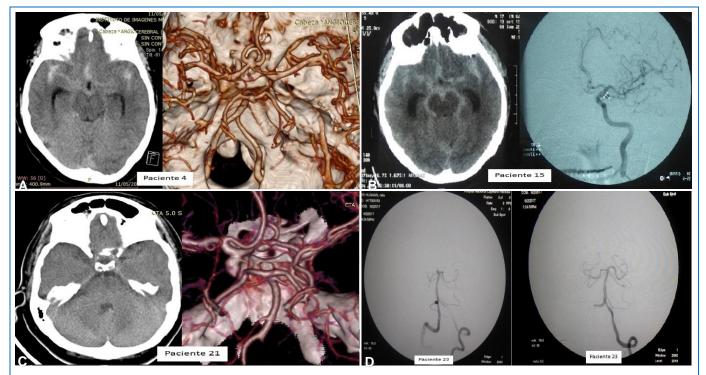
Computed tomography (CT), angioCT, and angiography of patients with cerebral aneurysms. (A) Brain CT showing SAH Fisher III. Brain angioCT showing an aneurysm in AComA. (B) Brain CT showing SAH Fisher III. Cerebral angiogram showing an unruptured left PComA aneurysm. (C) Brain CT showing SAH Fisher II. Brain angioCT showing a ruptured left PComA aneurysm and an unruptured AComA aneurysm. (D) Cerebral angiogram showing upper basilar aneurysm. Post-embolization control angiography with coils showing complete exclusion of the aneurysm.
